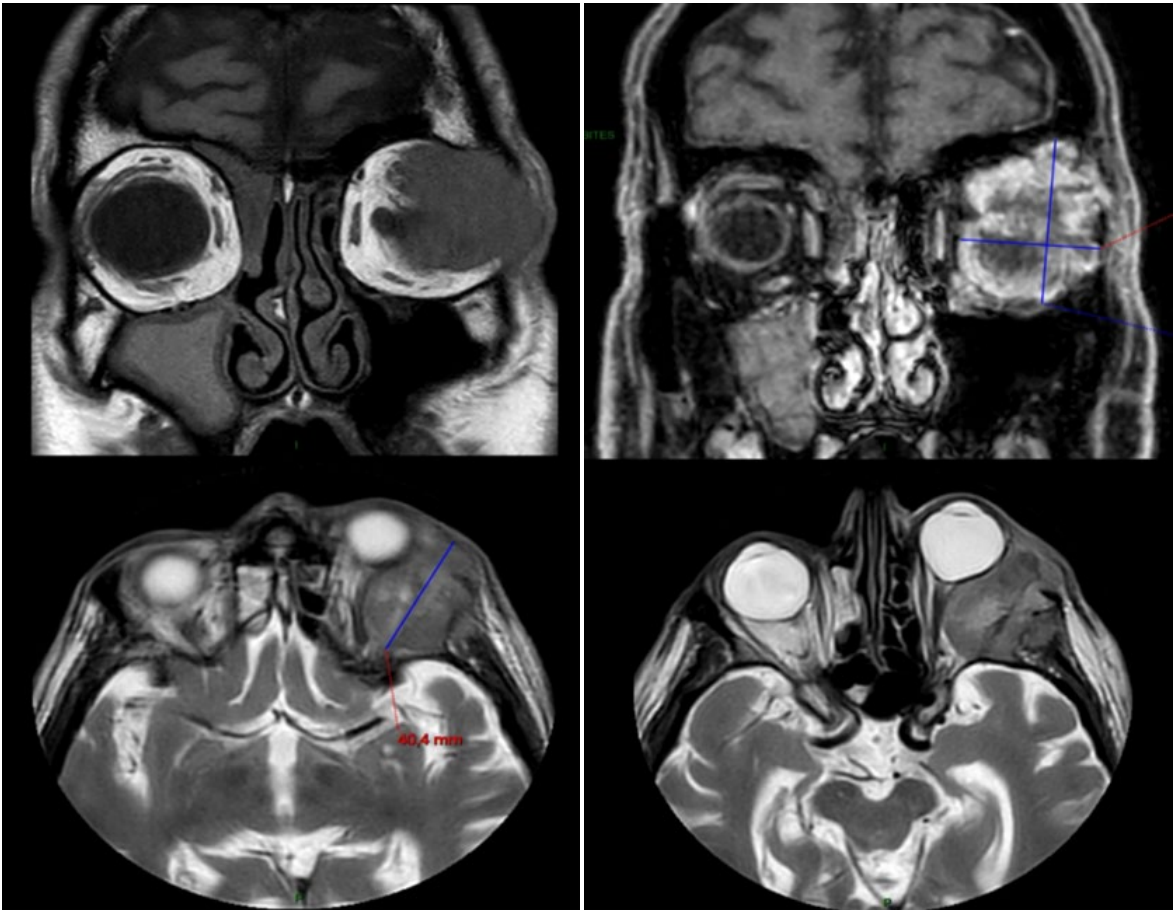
Initial MRI scans in coronal and sagittal views showed a left intraorbital pathological process invading the lateral orbital wall and the left temporal fossa. Grade III left-sided proptosis is evident.
